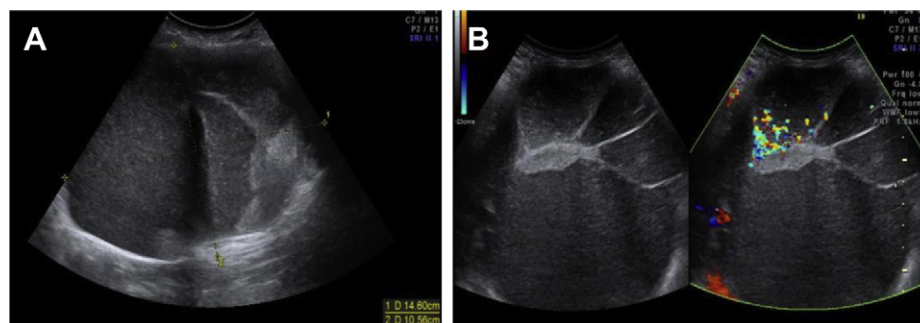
Ultrasound of pancreatic mucinous cystic neoplasm (MCN) performed in the ninth week of gestation. (A) Abdominal ultrasound demonstrating a large cystic mass (14 cm \times 11 cm) with septations and mural nodules. (B) Blood flow was present around the mural nodule and a hypertrophic septum in the tumor.
